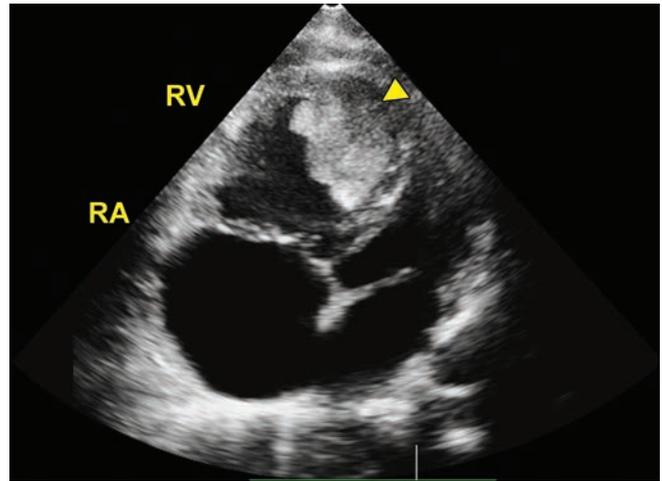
The RV mass (arrowhead) originating from the apex in 2D apical 4-chamber view.
